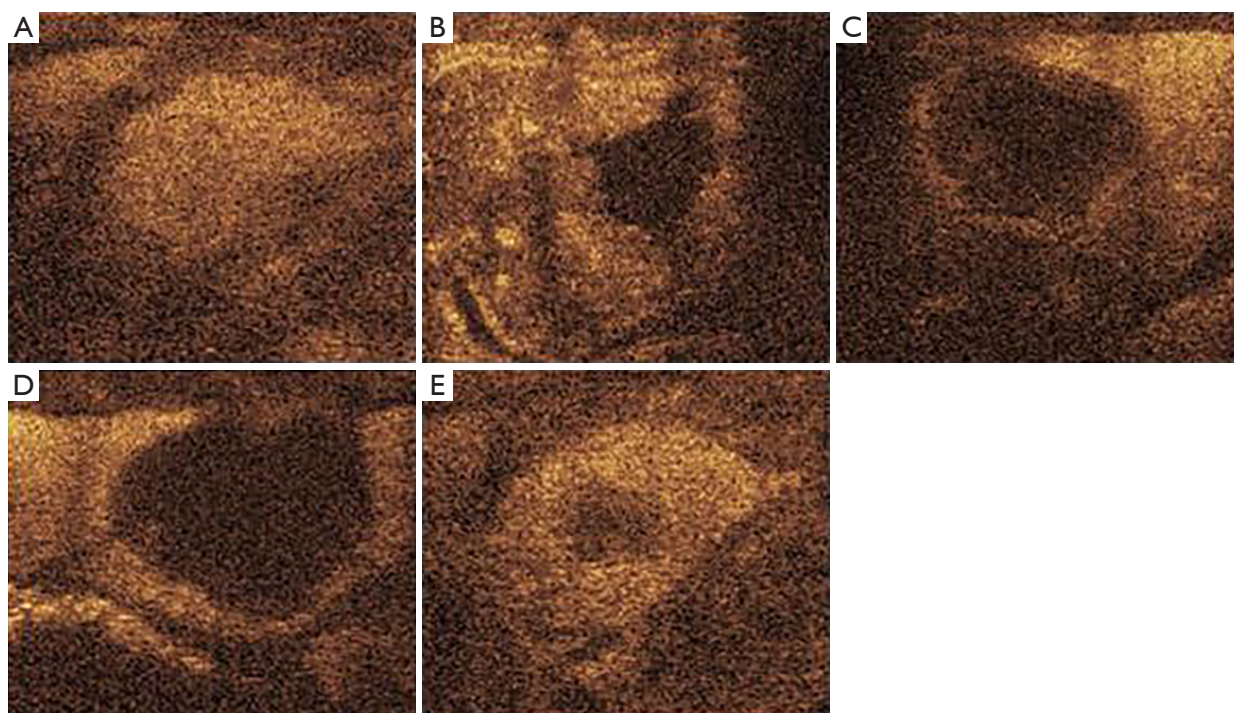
Contrast-enhanced ultrasound performance. (A) Saline group contrast-enhanced ultrasound images of the tumor. (B) Contrast-enhanced ultrasound images of Ablation zone in the absolute ethanol group. (C) Contrast-enhanced ultrasound images of Ablation zone in the 1.5-fold lauromacrogol group. (D) Contrast-enhanced ultrasound images of Ablation zone in the 2-fold lauromacrogol group. (E) Contrast-enhanced ultrasound images of Ablation zone in the 1-fold lauromacrogol group.
